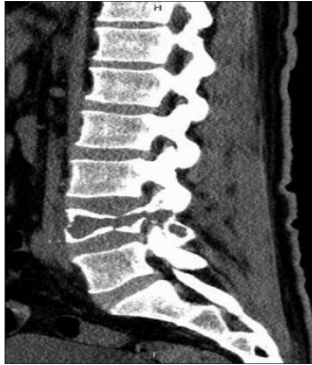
CT reconstruction image of plasmocytoma affecting L₄ vertebra
